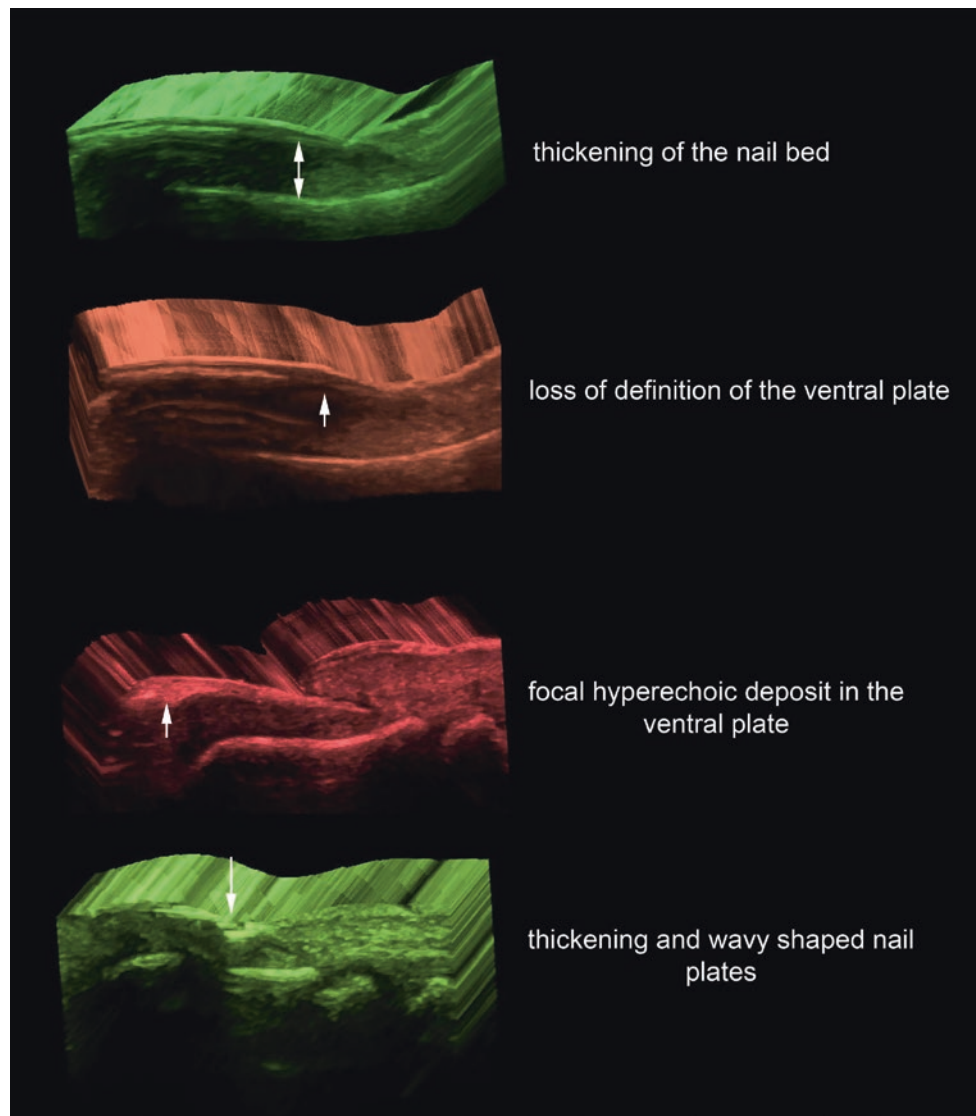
Nail psoriasis. 3D ultrasound reconstructions (longitudinal views) showing sonographic signs of psoriatic onychopathy.
